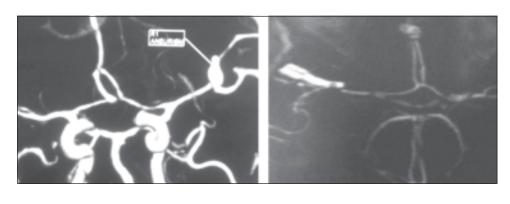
CT angiogram shows left MCA aneurysm (A) & Post-clip angiogram shows no residual aneurysm (B).
